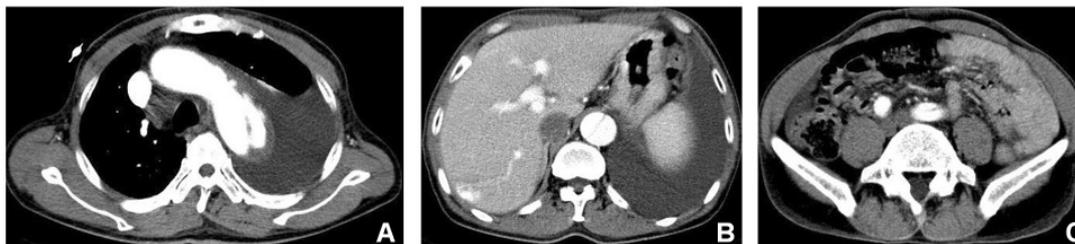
CT scan performed on December 4th 2009 showing no change in the dissection of the aorta. The thoracic and abdominal aorta diameters have remained stable (A, B, and C).
